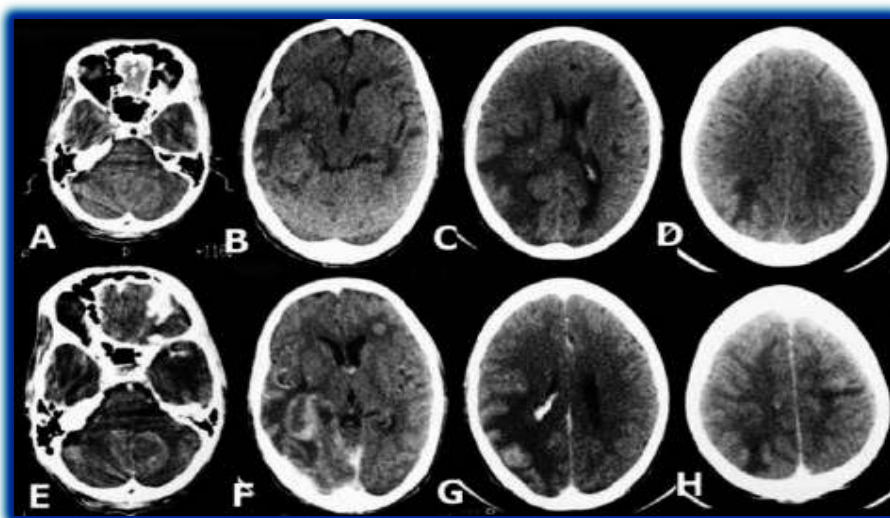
CT scan brain images
